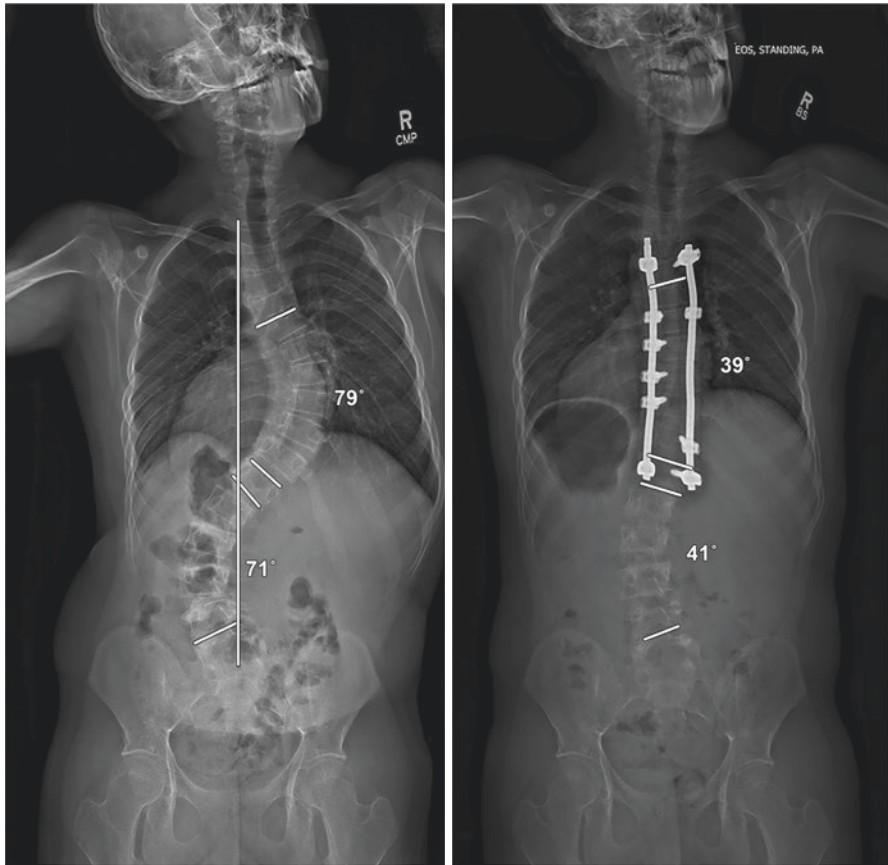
Pre- and post-operative AP radiographs of a patient treated with an instrumented selective thoracic posterior fusion
